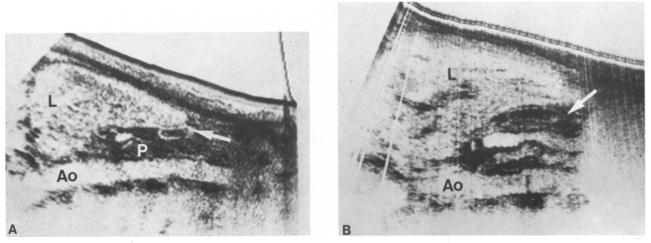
A Longitudinal sonogram showing the normal stomach (*white arrow*). The echogenic mucosa (black) is shown within the muscularis (light). L, left lobe of liver; P, pancreas; Ao, aorta. B Longitudinal sonogram showing the normal stomach (*white arrow*). From anterior to posterior note: left lobe of liver (L), collapsed stomach (*white arrow*), body of pancreas, superior mesenteric vein, superior mesenteric artery, aorta (Ao), anterior surface of spine. Note the echogenic (black) mucosa in collapsed lumen of the stomach and relatively echo-free (light) muscularis of the stomach
